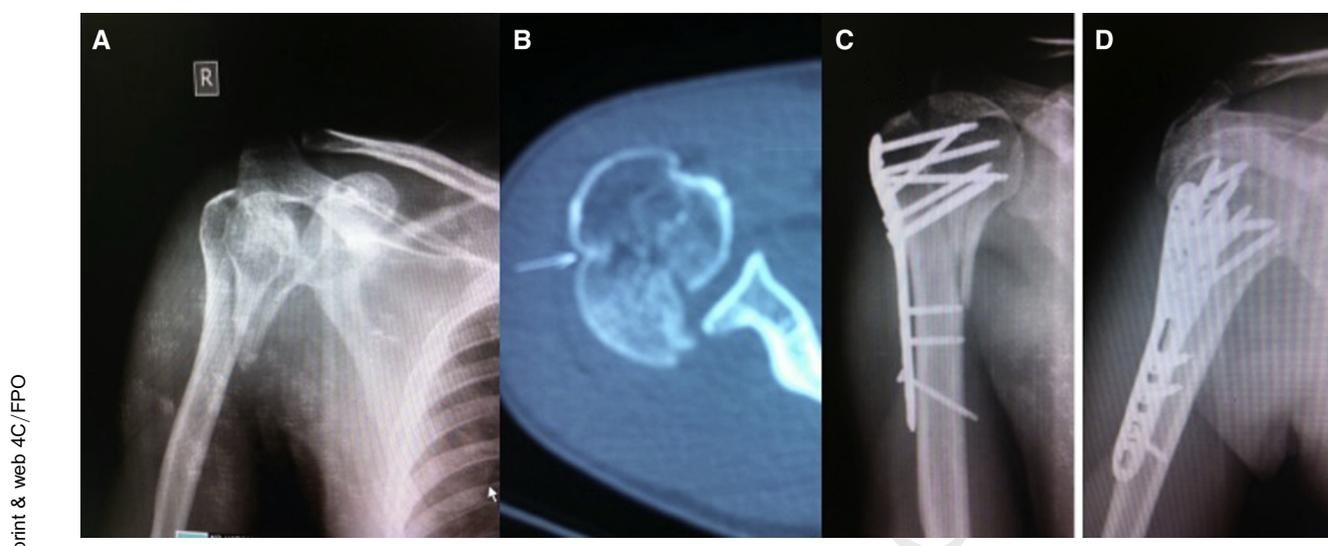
(A) Anteroposterior radiograph of a simple head-splitting fracture depicting a double head sign. (B) Axial CT shows the extent of the head split and a subluxed head fragment. (C and D) Follow-up radiographs show good reduction of the head and progressing union.
